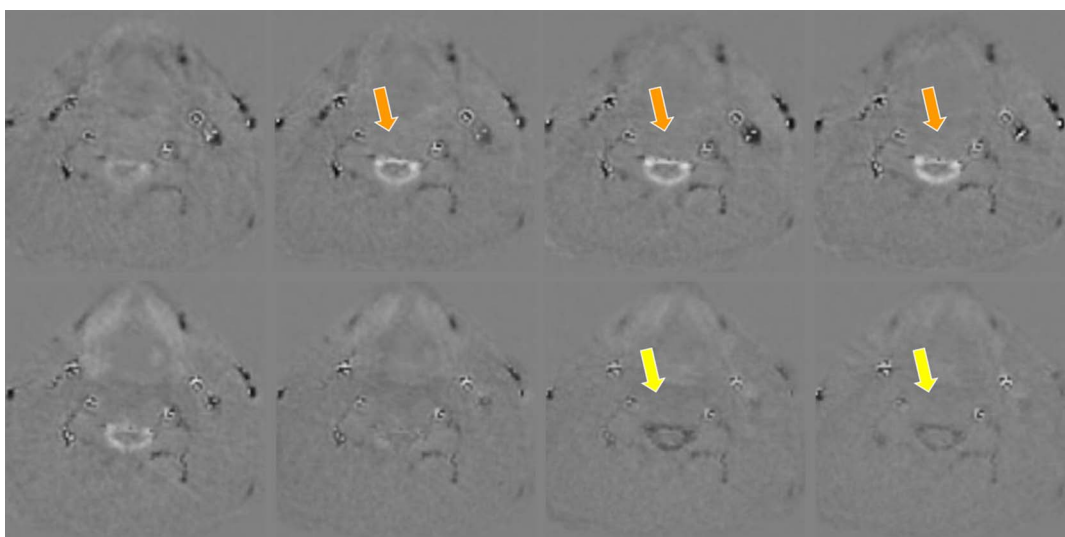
Quantitative velocity maps of CSF dynamics (model-based reconstruction as in Fig. 7). Consecutive frames (top left to bottom right, 1000 milliseconds period) of a real-time phase-contrast flow MRI movie of CSF flow in the cervical spinal canal during French horn playing (125 milliseconds acquisition time, 0.75 mm resolution, 5 mm slice thickness). During inspiration, CSF moves upwards (bright signal, orange arrows), whereas subsequent exhalation causes a downward flow (dark signal, yellow arrows), respectively.
